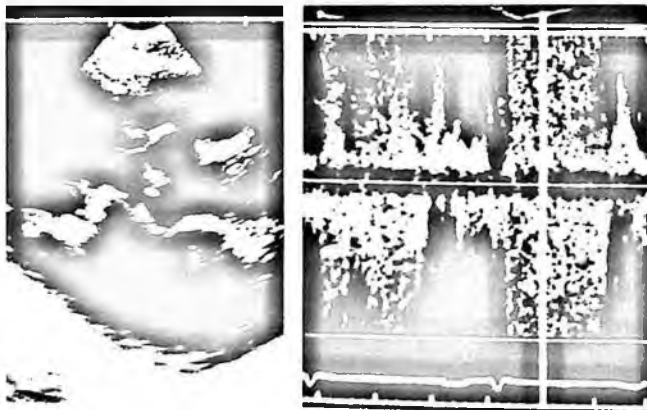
Expression of different modes of ultrasound cardiogram of rheumatic heart mitral stenosis; (1) Type-A; (2) Type-B, complicated with formation of blood embolus (left atrium); (3) M-mode, presenting "great wall-like" change; and (4) Type-C.
